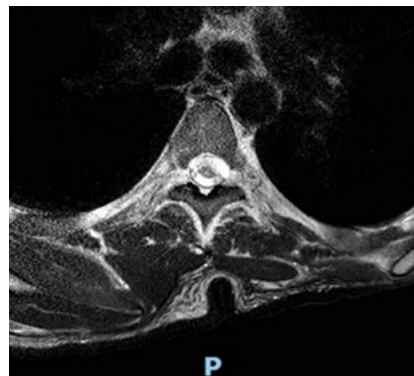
Axial T2-weighted MRI at T5 demonstrating the intrathecal baclofen fluid collection in the epidural space.
